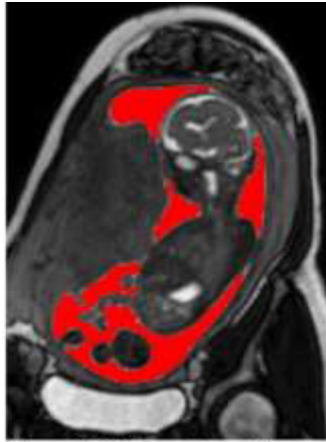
MRI image through the gravid uterus with computer-generated amniotic fluid volume (red) surrounding the fetus.
